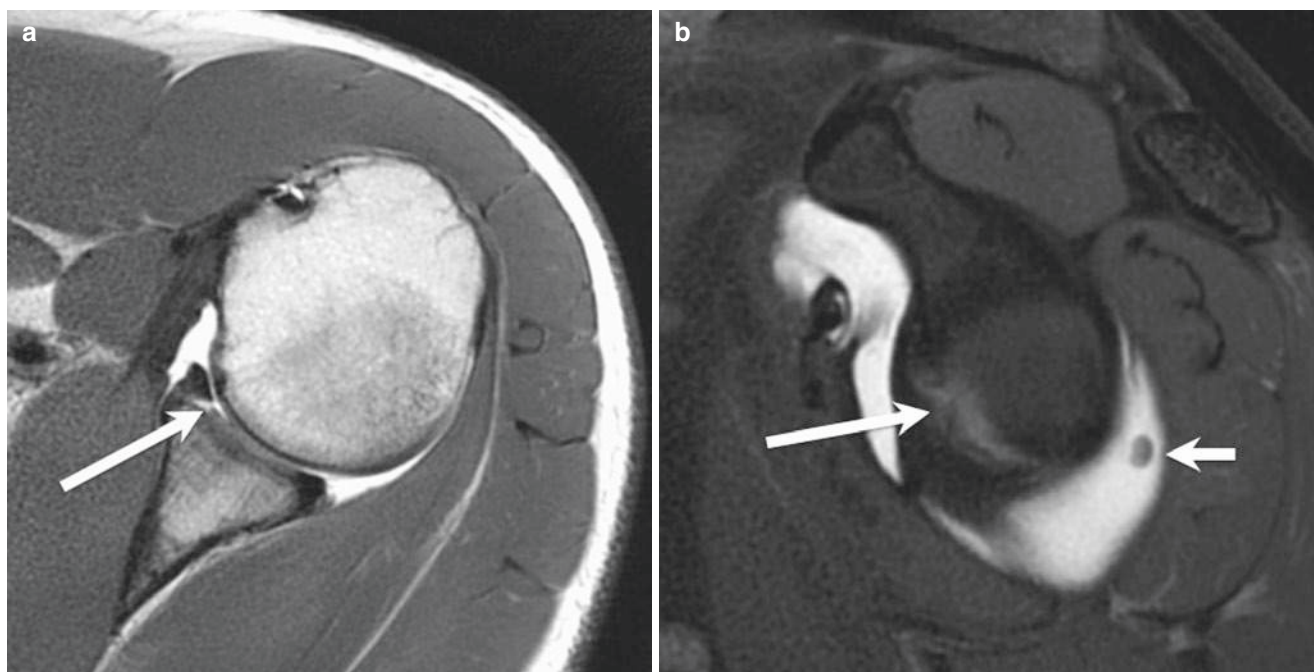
GLAD lesion. Axial T1-weighted (a) and sagittal oblique fat-suppressed T1-weighted (b) images demonstrate a GLAD lesion with an anteroinferior glenoid cartilage defect (*arrow* in a) and anteroinferior labral tear (*long arrow* in b) and loose cartilage fragment (*short arrow* in b)
